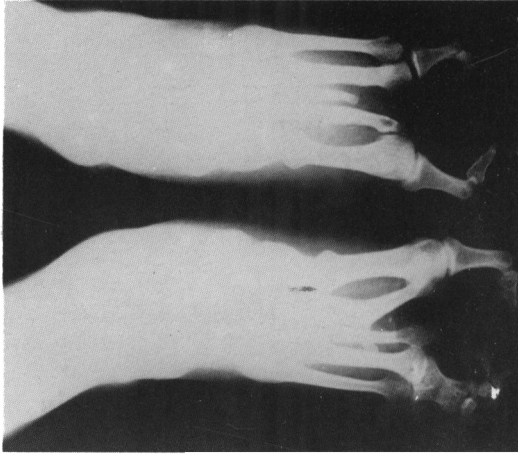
X-rays of P.S.'s feet.
